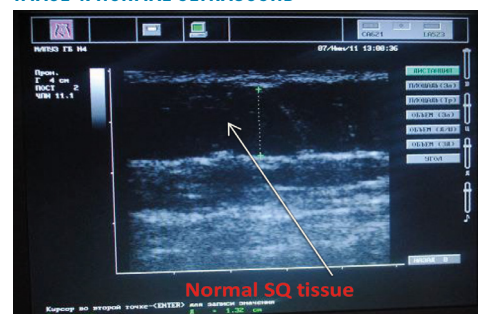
NORMAL ULTRASOUND
